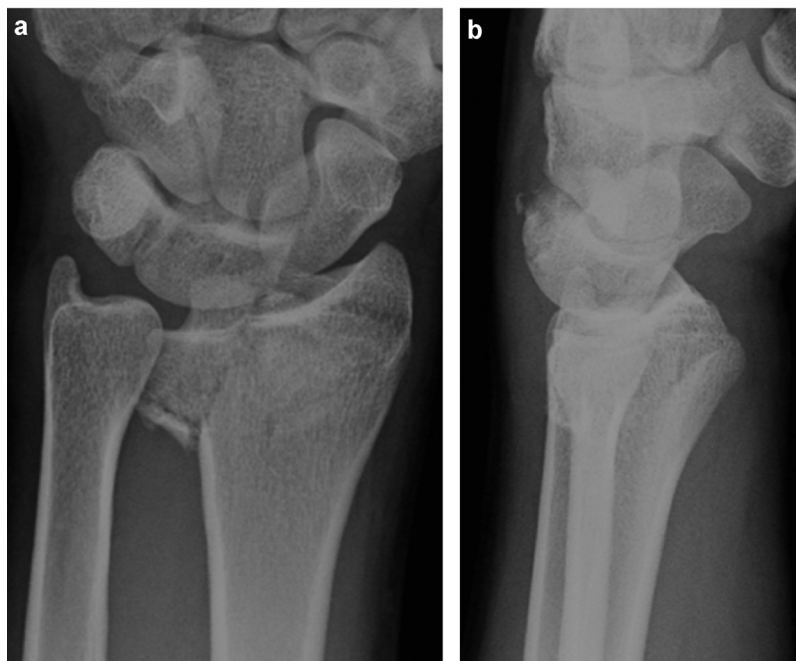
Preoperative X-rays. A/P radiograph showing damage to the radiocarpal and distal radio-ulnar joints (a). Standard lateral radiograph showing an intra-articular distal radius fracture with dorsal triquetral ligament detachment; VISI also possible (b). The same patient's case is featured in all the figures that follow.
